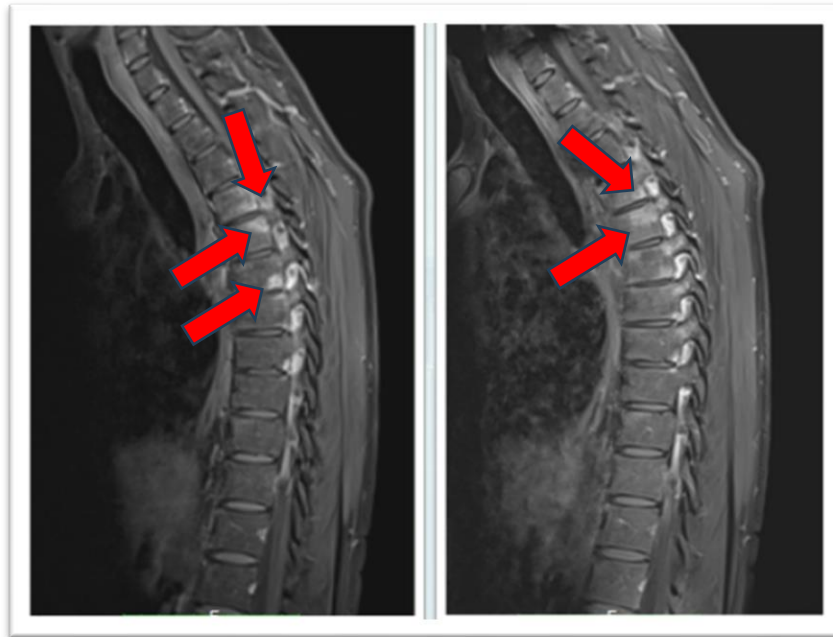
Sagittal MRI with STIR sequences: confirmation of areas of altered signal intensity (arrows).
